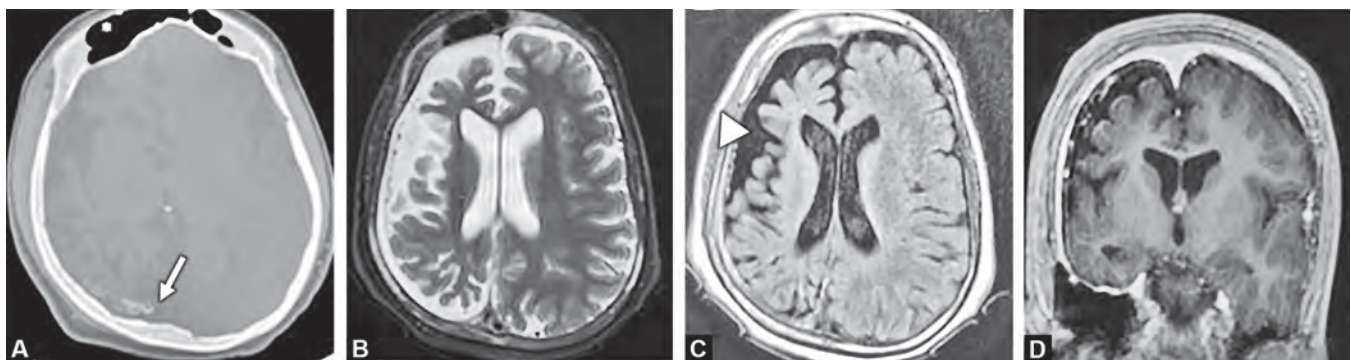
(A) Axial non-contrast CT brain in bone window depicting serpentine calcifications along the gyri (arrow) involving the right cerebral hemisphere, with adjacent calvarial thickening and ipsilateral dilated frontal sinus. (B) Axial T2WI demonstrates right cerebral atrophy. (C) Axial FLAIR shows dirty CSF (arrowhead) in the subarachnoid space with serpentine hyperintensities- “ivy sign”. (D) Post-contrast axial T1 images show pachymeningeal enhancement
